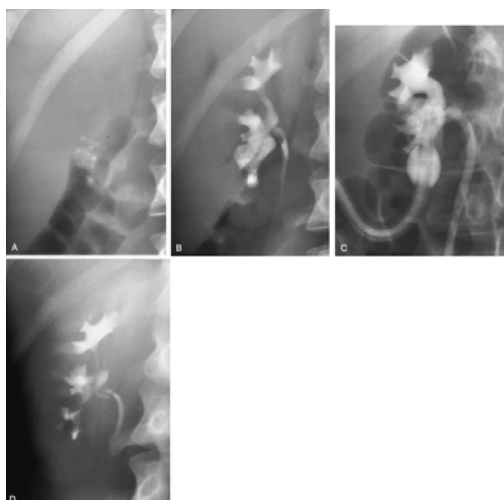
A: Plain radiograph reveals multiple stones in the lower pole of the right kidney following failed shock wave lithotripsy performed 2 years earlier. B: Intravenous pyelography reveals dilation of the involved lower infundibulocalyceal system as a result of localized infundibular stenosis. C: Direct access to the involved infundibulum allows direct stone removal. The infundibulum was then dilated percutaneously and a nephrostomy tube left across the infundibulum into the renal pelvis. D: Follow-up urogram reveals complete resolution of the localized hydrocalices following percutaneous dilation of the infundibular stenosis.
